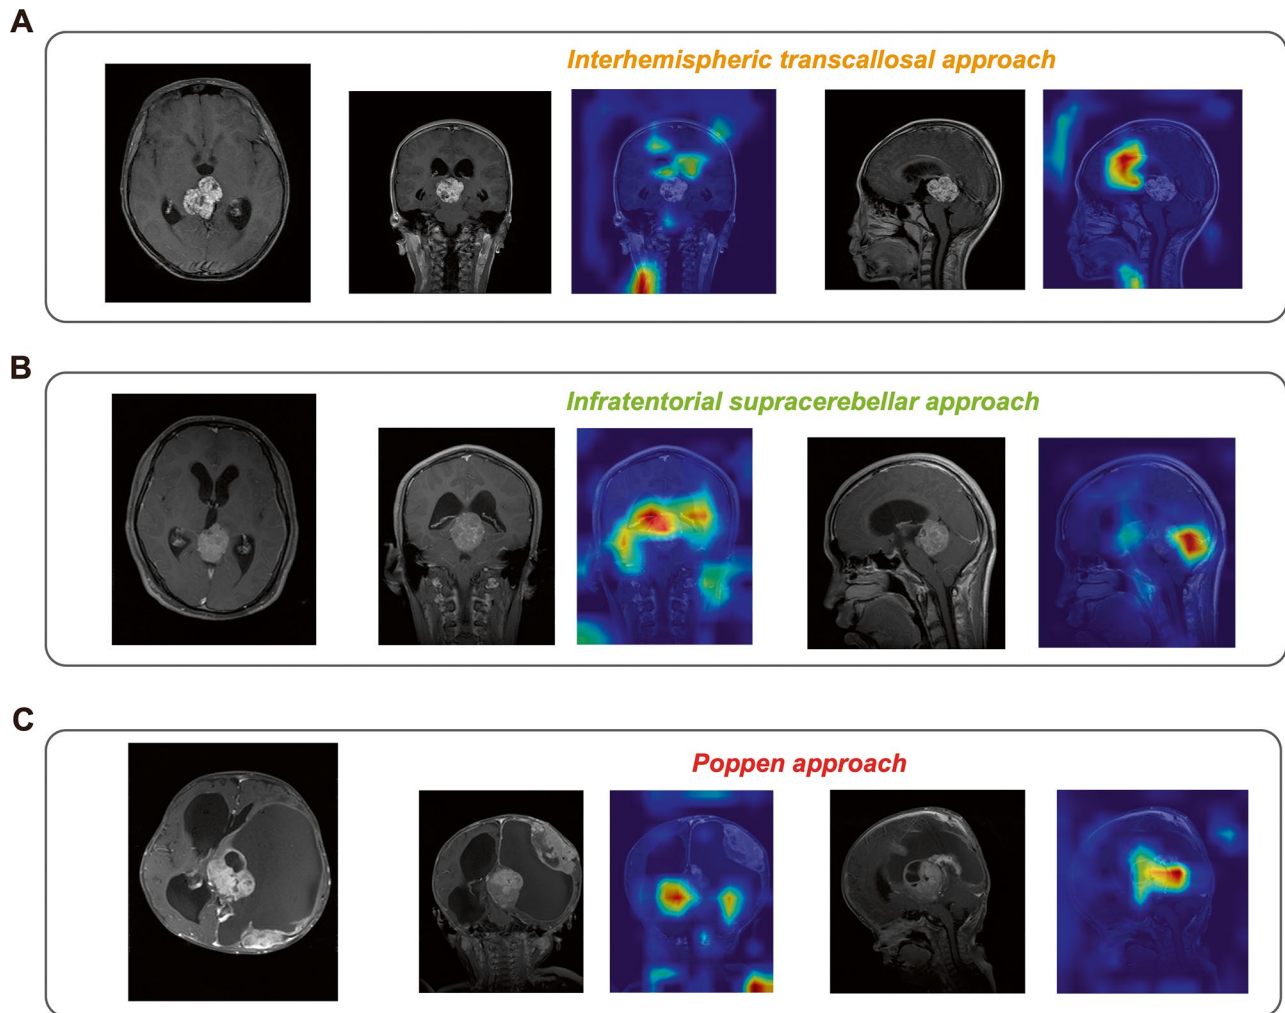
Grad-CAM visualization of EfficientNetV2-m for PRTs is depicted in (A), (B), and (C), showcasing MRI images from different orientations along with the corresponding class activation maps for patients undergoing ITA, ISA, and PA surgeries, respectively
